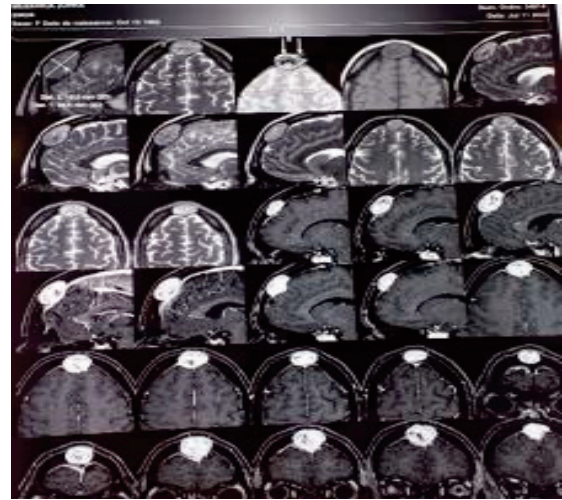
cerebral MRI found a tumor tissue mass of 32x25mm developed within the median diploe of the frontal bone, it appears in hypo signal T1, moderate hypersignal T2, with intense enhancement, moderately heterogeneous by the presence of central micro calcifications.
